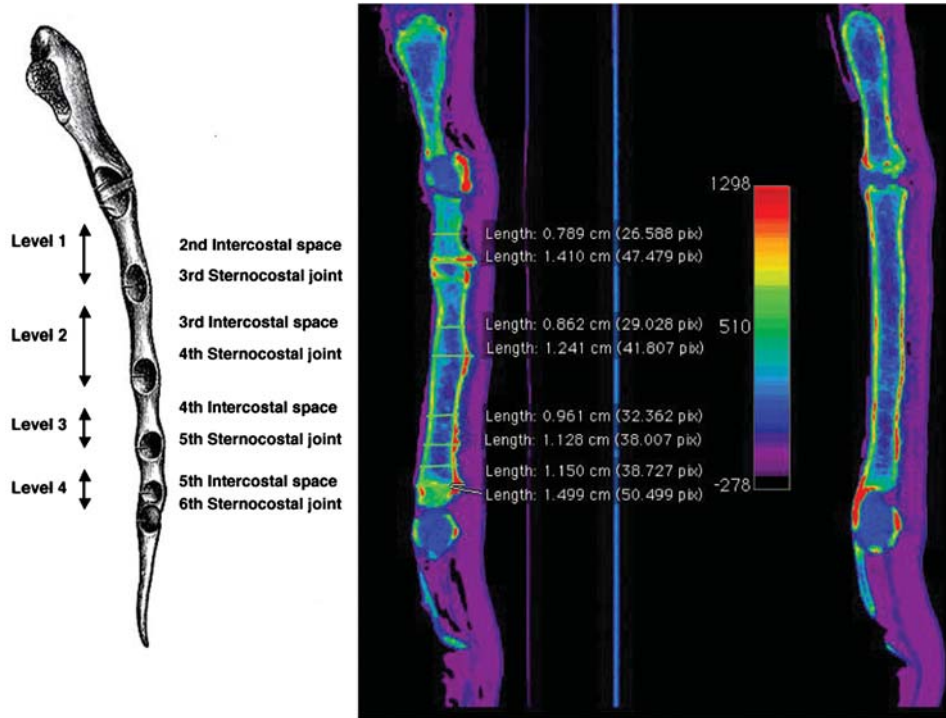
The picture on the left shows a lateral view of the sternum (after Gray's Anatomy 1918 edition) and shows four levels—each level represents alternative sites for the insertion of four different wires in the body of the sternum. The thicker one of each pair is called a ridge at the level of the sterno-costal joints, while the thinner site is called a valley at the level of the intercostal space. The middle picture is a thin slice CT of the lateral paramedian part of the sternum. It shows four pairs of measurements at each of the levels in the sternal body. The scale shows radio-density with red being the most dense in this 'UCLA' CLUT. Of note the radio-density is highest at the sterno-costal levels (ridges). The picture on the right shows a thin slice CT of the midline aspect of the same sternum where the striking feature is the homogeneity of the sternal thickness.
